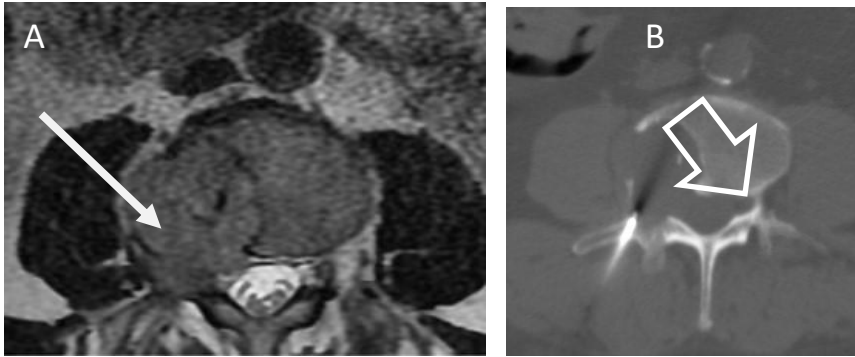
A) A 70-year-old male patient with a lytic lesion in the right pedicle of the L3 vertebral body, as indicated by the solid white arrow. B) CT-guided biopsy of the lesion confirmed a diagnosis of plasma cell neoplasm.
